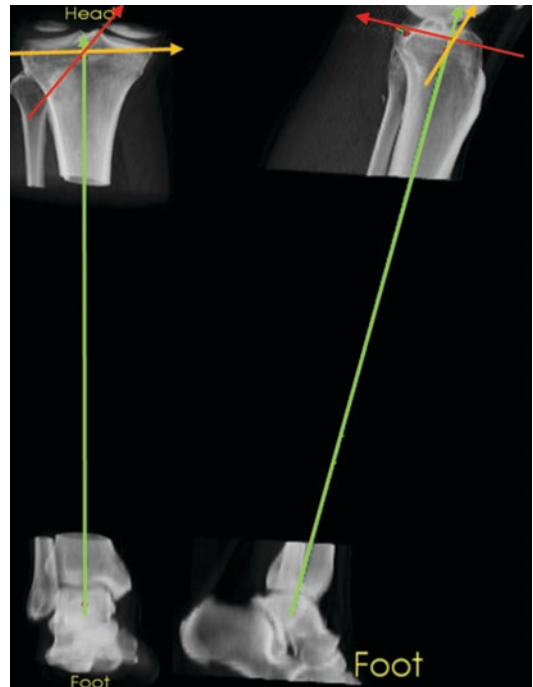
3D reconstructed CT images of a patient’s knee and ankle joint. The frame of reference as defined in the text is shown in anterior-posterior (x-axis in green, z-axis in yellow, y-axis in red) and medial-lateral (x-axis in green, z-axis in yellow, y-axis in red) view
